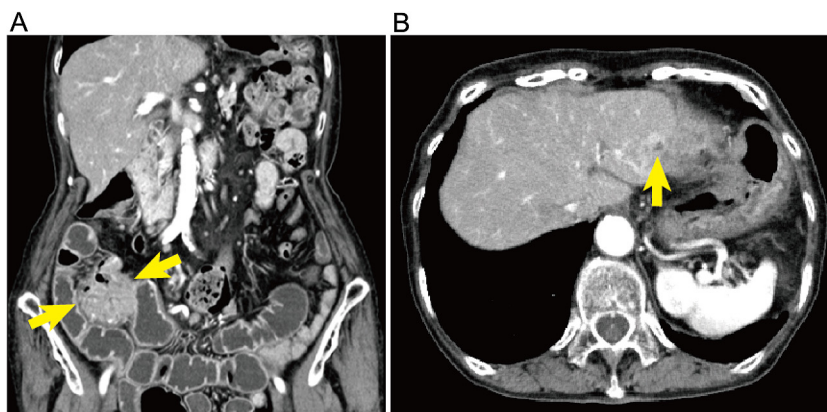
Abdominal CT revealed an irregular mass enhanced heterogeneously in the right side colon with size of 5 × 4 cm (A) and a liver tumor in the segment III (B).
